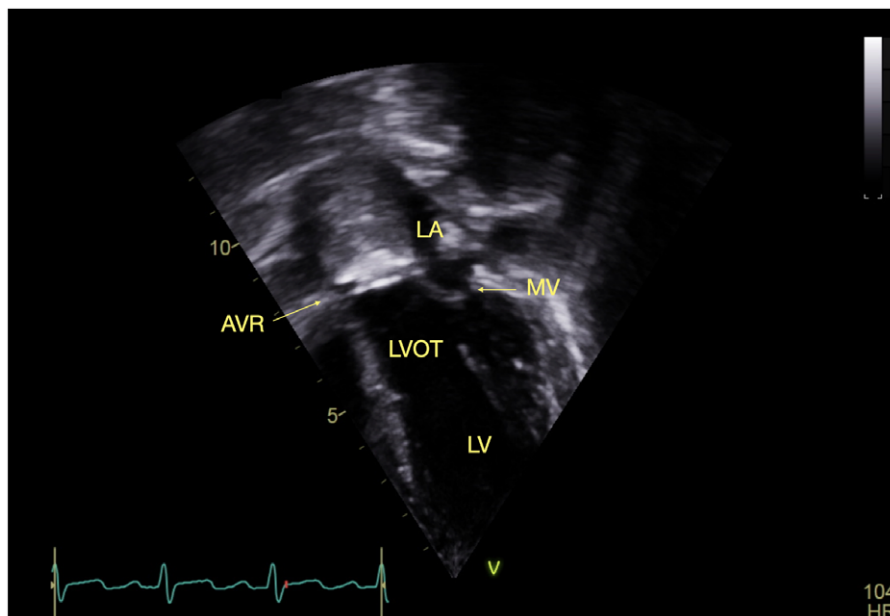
Transthoracic echocardiogram four chamber view demonstrating On-X valve in situ.
